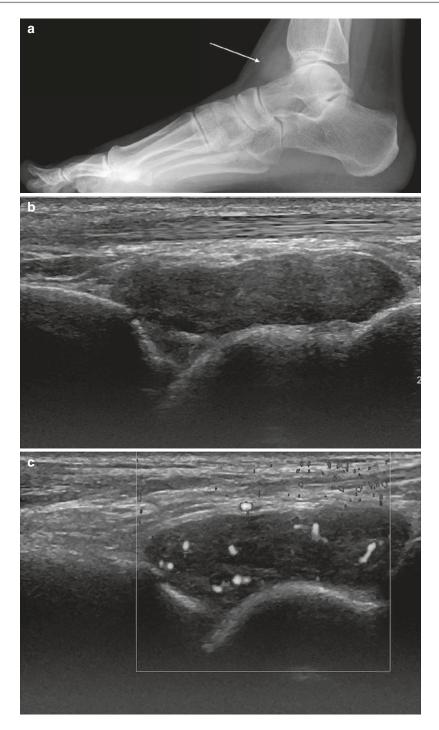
(a–e) Localised nodular synovitis (*LNS*) of the ankle. (a) Radiograph. (b) Longitudinal ultrasound. (c) Longitudinal power Doppler ultrasound. (d) Sagittal T1-weighted MR image. (e) Sagittal STIR MR image. A dense well-defined soft tissue mass (*arrow*) is seen in the anterior recess of the tibiotalar joint (a). *LNS* on ultrasound is seen as a heterogeneous solid intra-articular
